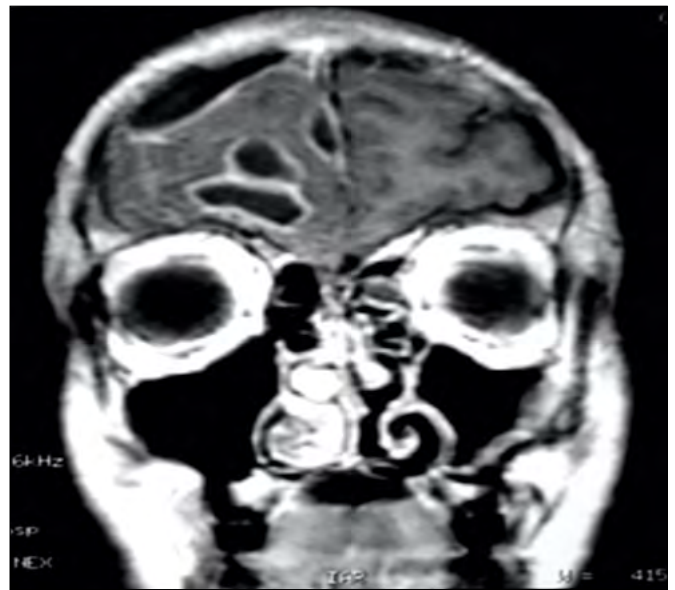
MRI showing a huge abscess in the right frontal lobe.
